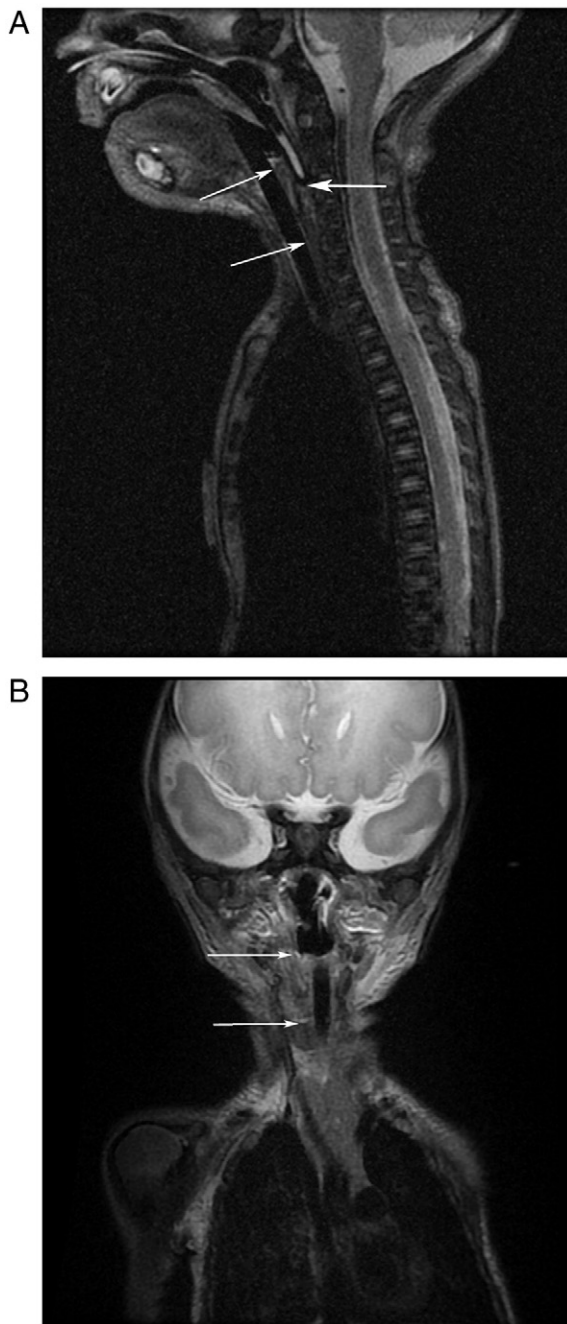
T2-weighted sagittal (A) and coronal (B) MRI of Case 1. On sagittal view, the tip of the blind ending esophagus with nasogastric tube in place is indicated by the right arrow, while the mass borders are indicated by the left arrows. The coronal image better demonstrates the mass with its proximal and distal extents (arrows).
